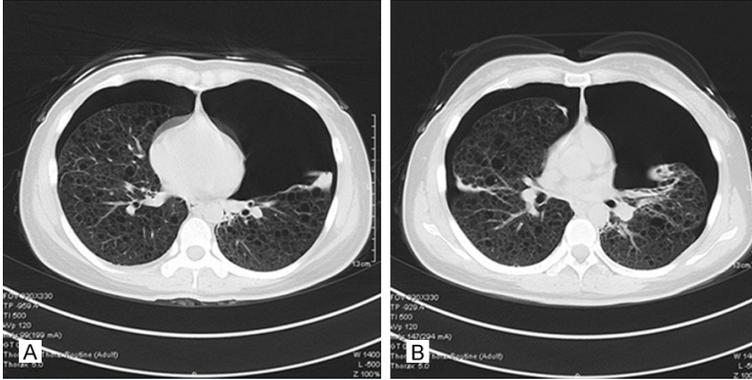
A and B: A high-resolution CT scan showed that both lungs had extensive and well-distributed cystic lucency shadows and uniform, thin-walled complete follicular cavity. Most of the shadows were round or semi-round and surrounded by normal lung tissues. They were evenly distributed in both lungs.
